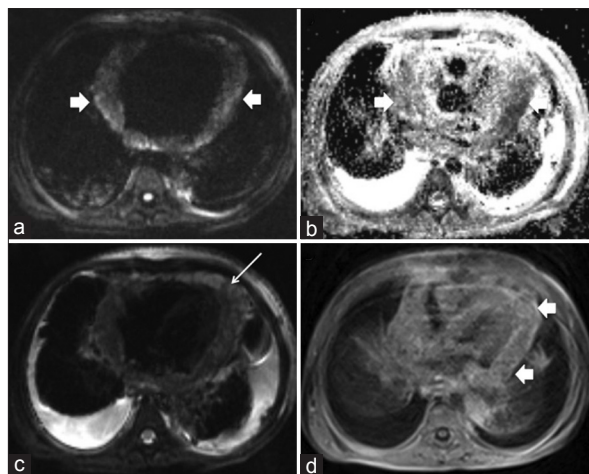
Cardiac magnetic resonance imaging of the patient. (a and b) Four-chamber diffusion-weighted sequence and apparent diffusion coefficient (ADC) maps showing diffusion-restricted areas in the pericardium (arrows). (c) Four-chamber T2-weighted sequence (TR-5916 ms: TE-78 ms: FOV 324*384: slice thickness – 8 mm) showing multiple focal hyperintense pericardial abscesses (thin arrow). Also note the bilateral pleural effusion. (d) Delayed T1-weighted contrast-enhanced image (TR-500: TE-7.2: FOV 324*384: slice thickness – 8 mm) demonstrating multiple pericardial abscesses that shows peripheral ring-like contrast enhancement (arrows)
